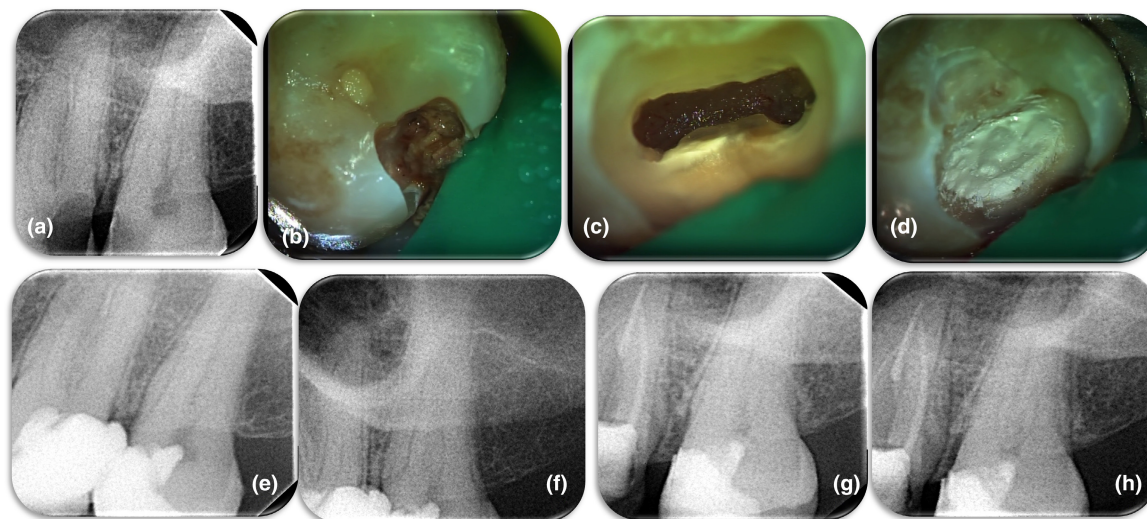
(a) Initial radiograph of a mature second mandibular molar of a 43-year-old patient with large caries at the mesial surface, the tooth is very sensitive to percussion, (b) clinical figure of the deep caries after tooth isolation, (c) clinical appearance of the pulp tissue after control of bleeding, (d) placement of Total Fill BC over the remaining coronal pulp tissue, (e, f) Postoperative radiographs of the case, (g, h) 24-month recall radiographs. Formation of dentinal bridge is apparent. Due to great length of the roots, two radiographs were considered essential for the evaluation of periapical tissues and coronal restoration.
